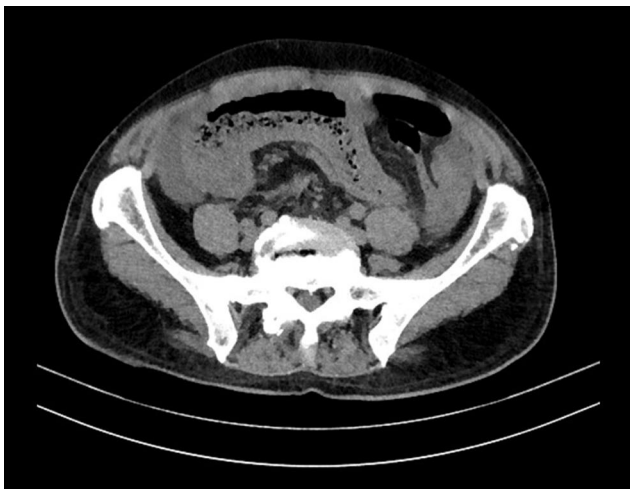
Abdominal CT of case no. 4.
